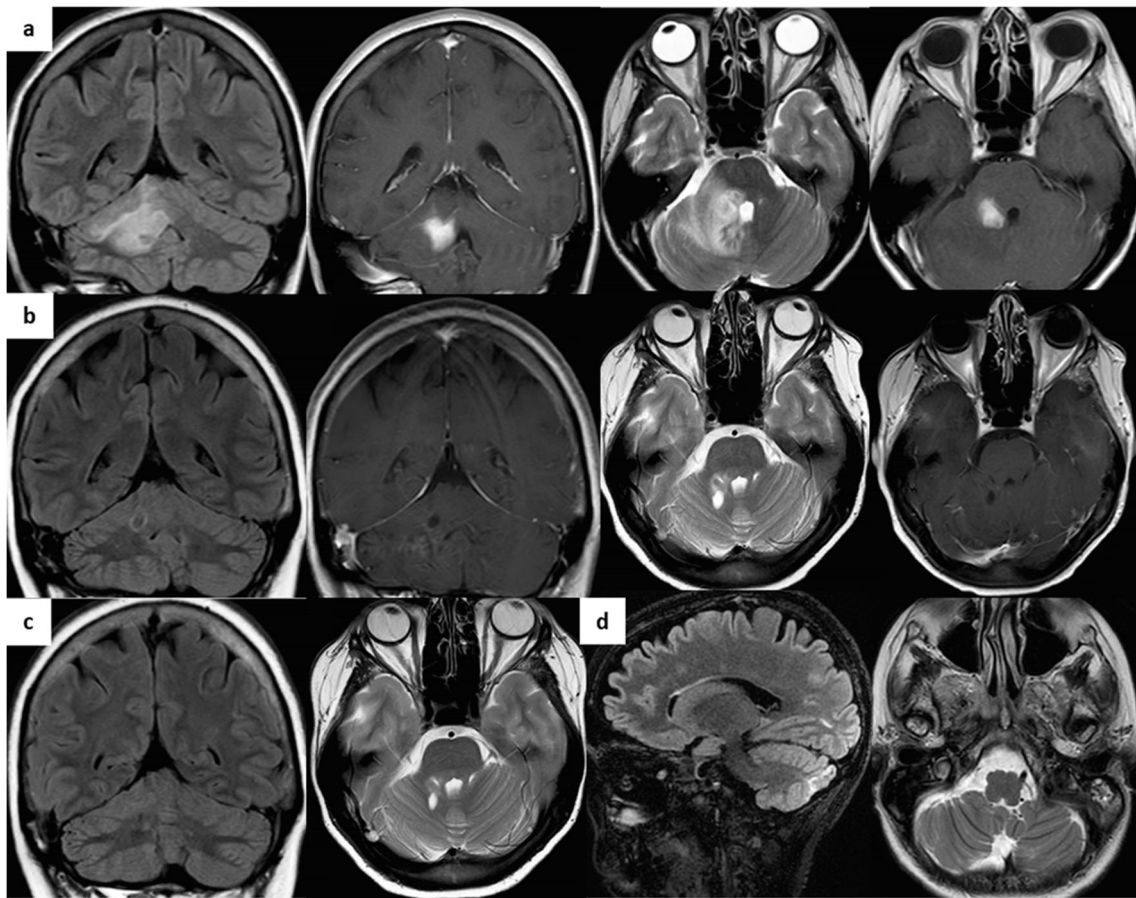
Brain MRI in cases 1 and 2. a Case 1 right middle cerebellar peduncular mass with surrounding edema (left, coronal views with and without gadolinium; right, axial views with and without gadolinium); b Case 1 reduction in the mass size post-treatment (left, coronal views with and without gadolinium; right, axial view with and without gadolinium).
